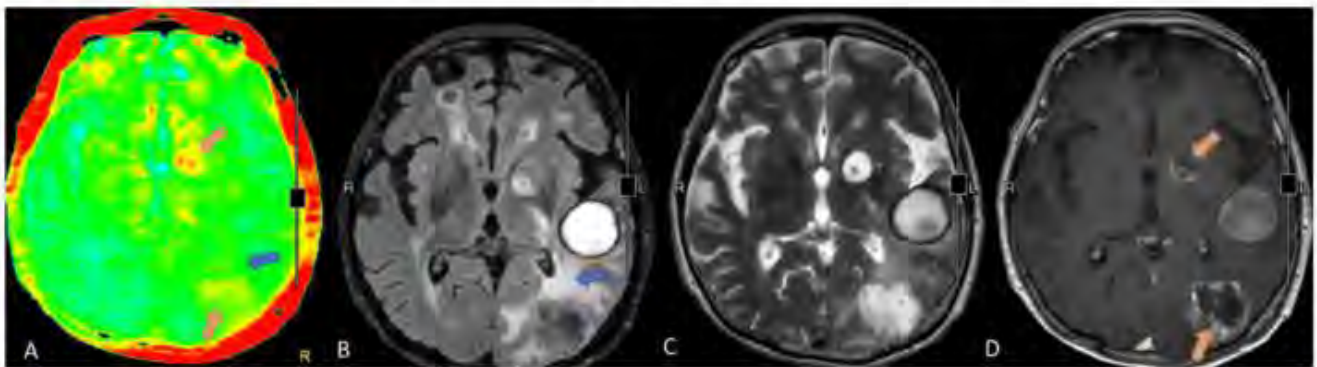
APT-weighted and conventional MR images of a 68-year-old female with 2 rim-enhancing metastatic breast cancer lesions at left occipital and left basal ganglia. APT color map (A) showed yellow color corresponding with enhancing component of these 2 lesions on Gd-enhanced T1W-image (D) (orange arrow). The perilesional hyperintense on FLAIR (B) and T2W (C) at left temporo-occipital region show green color on APT color map (A) (blue arrow) which indistinguishable from the normal brain background.
